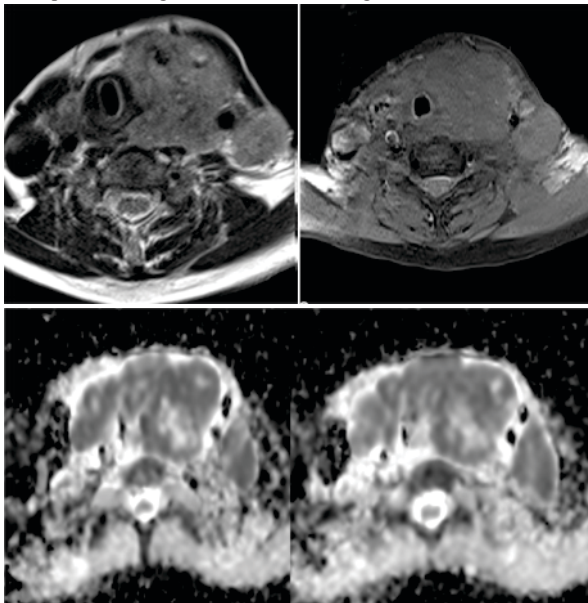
Ill-defined lesion of heterogenous signal intensity diffusely involving the thyroid parenchyma on 4A-T2WI, 4B-T1WI and areas of diffusion restriction on 4C and 4D-DWI
